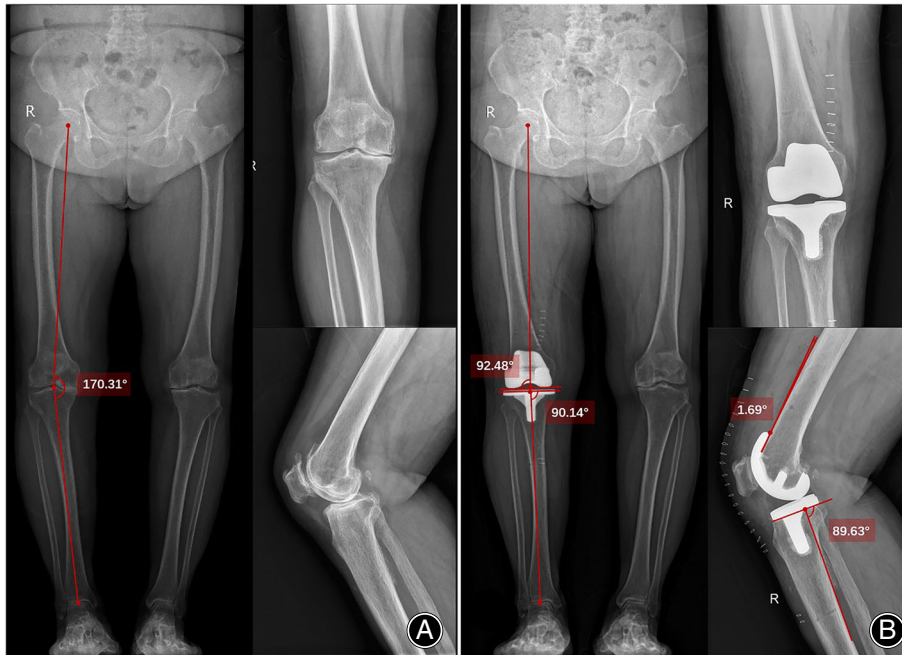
Radiographs of a 64-year-old female patient who underwent navigation-assisted TKA using the aMA technique. (A) Preoperative standing full-leg X-ray (EOS) showed an osteoarthritis right knee with 170.31° varus. (B) EOS at 1 week postoperatively showed a restored knee with an angle of 2.53° varus. The cFCA was 92.48°, the cTCA was 90.14°, the sFCA was 1.69°, and the sTCA was 89.63°.
